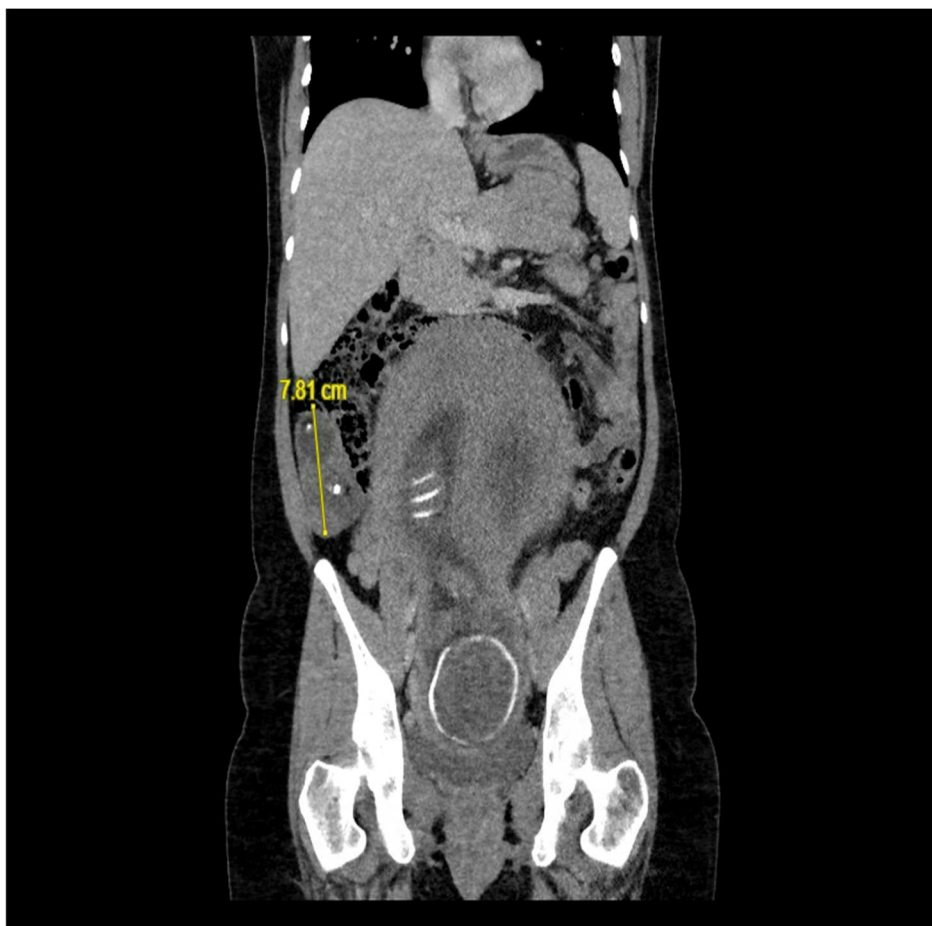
Ovarian Mass on CT scan coronal image
